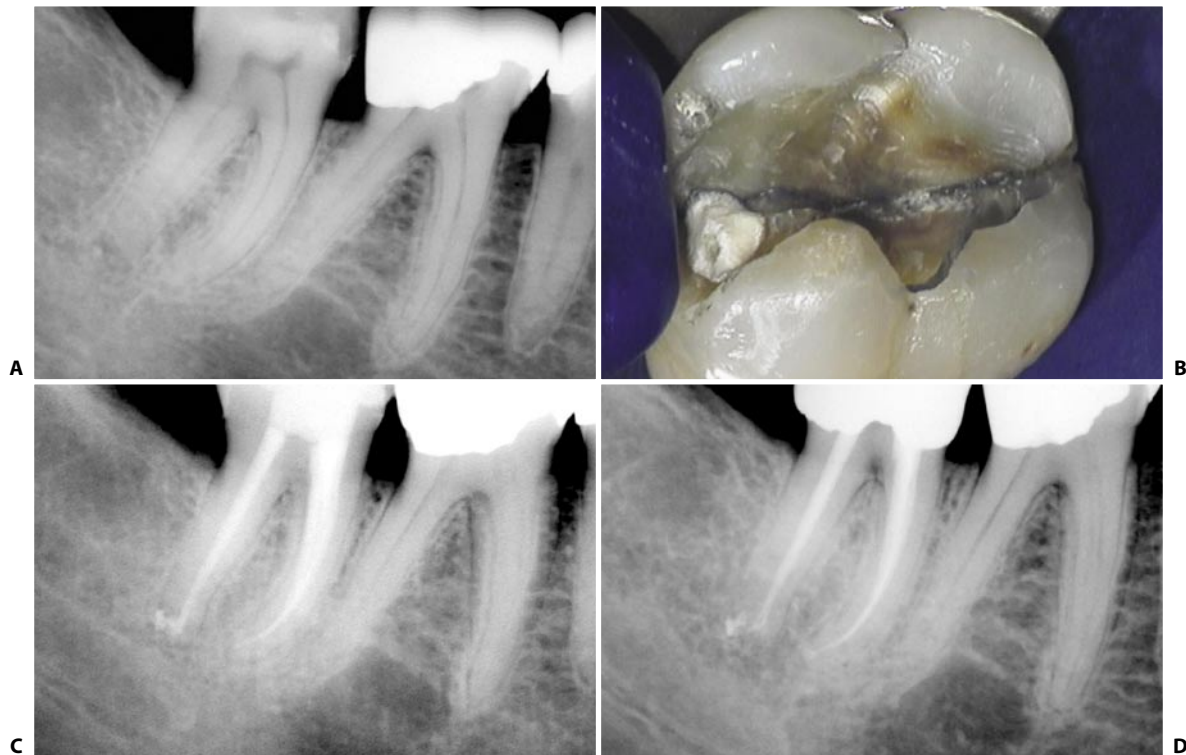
A. Preoperative radiograph. The patient was sent as an emergency from the general practitioner's office. The chief complaint was "tenderness to mastication and discomfort to cold." B. A dark hairline is running from mesial to distal, indicating a possible crack of long standing. Symptoms did not subside and endodontic treatment was performed. C. Postoperative radiograph. D. Two year recall.
